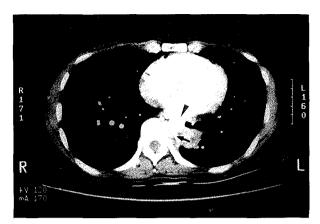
Spiral CT shows the drainage vein (arrow) to the hemiazygus vein in the same patient.
